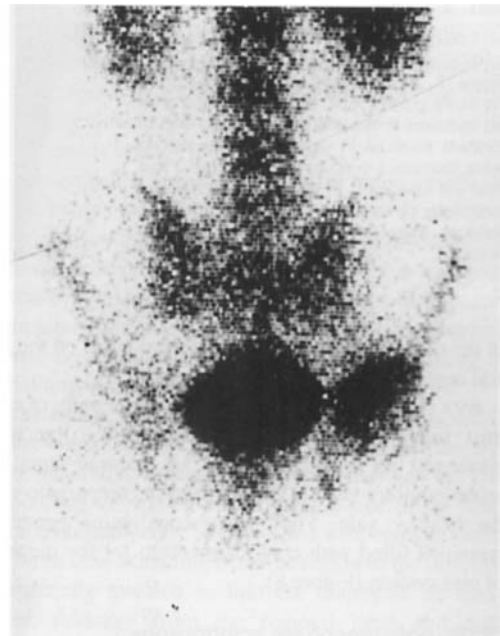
^{99m}Tc -polyphosphate scintigraph from patient with arthrosis of the left hip.
